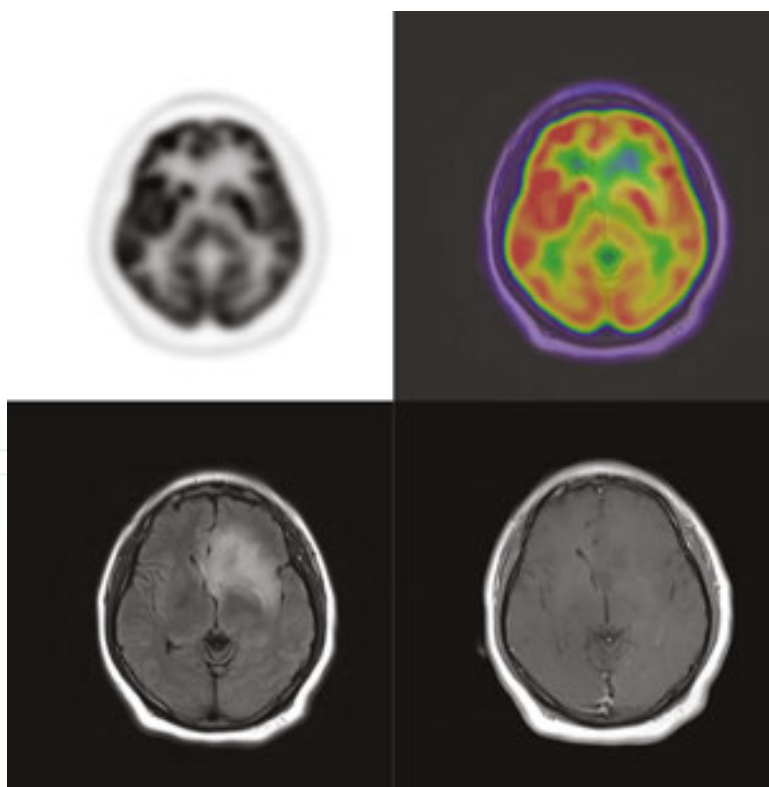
FDG uptake in a left frontal cerebral glioma on PET/CT. *Top row:* The tumour is not readily discernible from intense physiological FDG activity in the adjacent cerebral parenchyma. *Bottom row:* The tumour is much better depicted on MRI FLAIR imaging (*bottom left panel*) and shows no contrast enhancement due to its low grade (*bottom right panel*).
